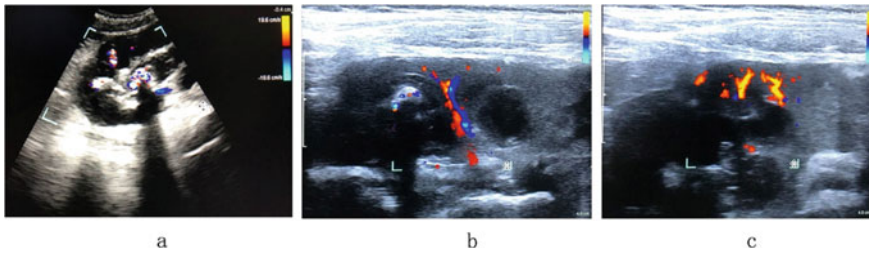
a, b, c: Infant kidney structure and vessels under ultrasound scan. Image from low-frequency convex array probe (3a), image from high-frequency linear array probe (3b, c)
